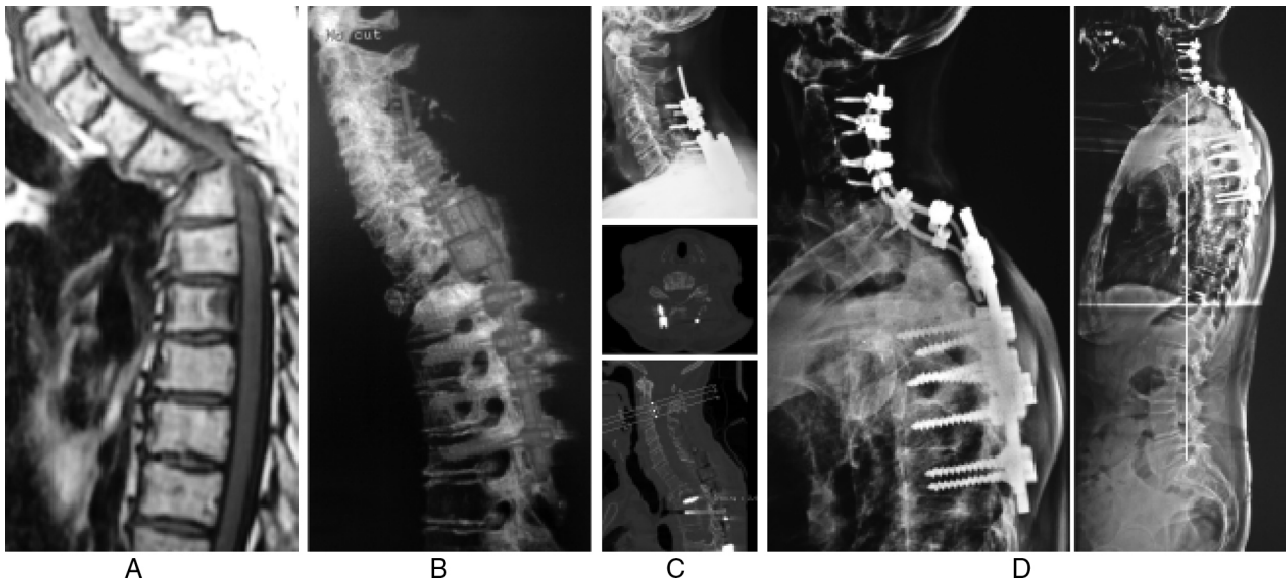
Angular kyphosis due to pathological fracture of T3 after multiple myeloma treatment. Paraparetic patient with strength grade III. (A) Initial appearance on magnetic resonance imaging with 70° of T2-T4 kyphosis and spinal cord compression. (B) Postoperative tomography showing good correction of the deformity. (C) Radiograph and tomography made after discharge due to sudden increase in cervical pain. The exams show pulling of the screws in the lateral cervical masses, with little loss of correction. (D) Final aspect after a new approach, in which the dorsal screws were maintained and the cervical implants replaced, with extension of the fixation up to C2. The orthostatic radiograph shows the C7 plumb line exactly on the posterior aspect of the sacral plateau (case 8).
